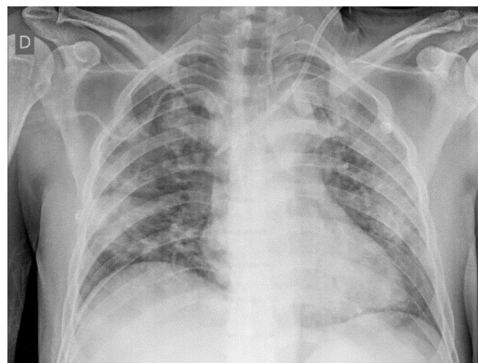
Chest x-ray taken on hospitalization day 6: diffuse alveolar pattern.
